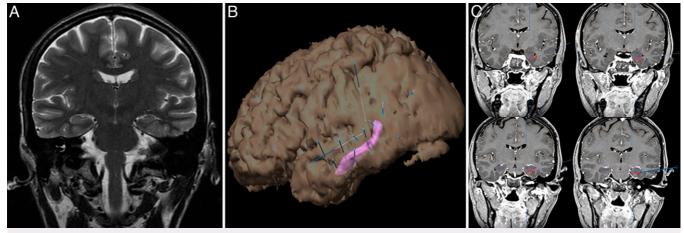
A: Pretreatment coronal T2-weighted MRI sequence depicting the absence of hippocampal changes. B: Lateral reconstruction of left-sided sEEG implantation depicting trajectories of 12 electrodes. The amygdala and hippocampus are highlighted in purple. C: Coronal reconstructions of sEEG electrodes that captured ictal activity during seizure onset, located in the amygdala, hippocampus, and parahippocampal gyrus. All four electrodes were involved in each captured seizure event. Red indicates positions of ictal contacts.
